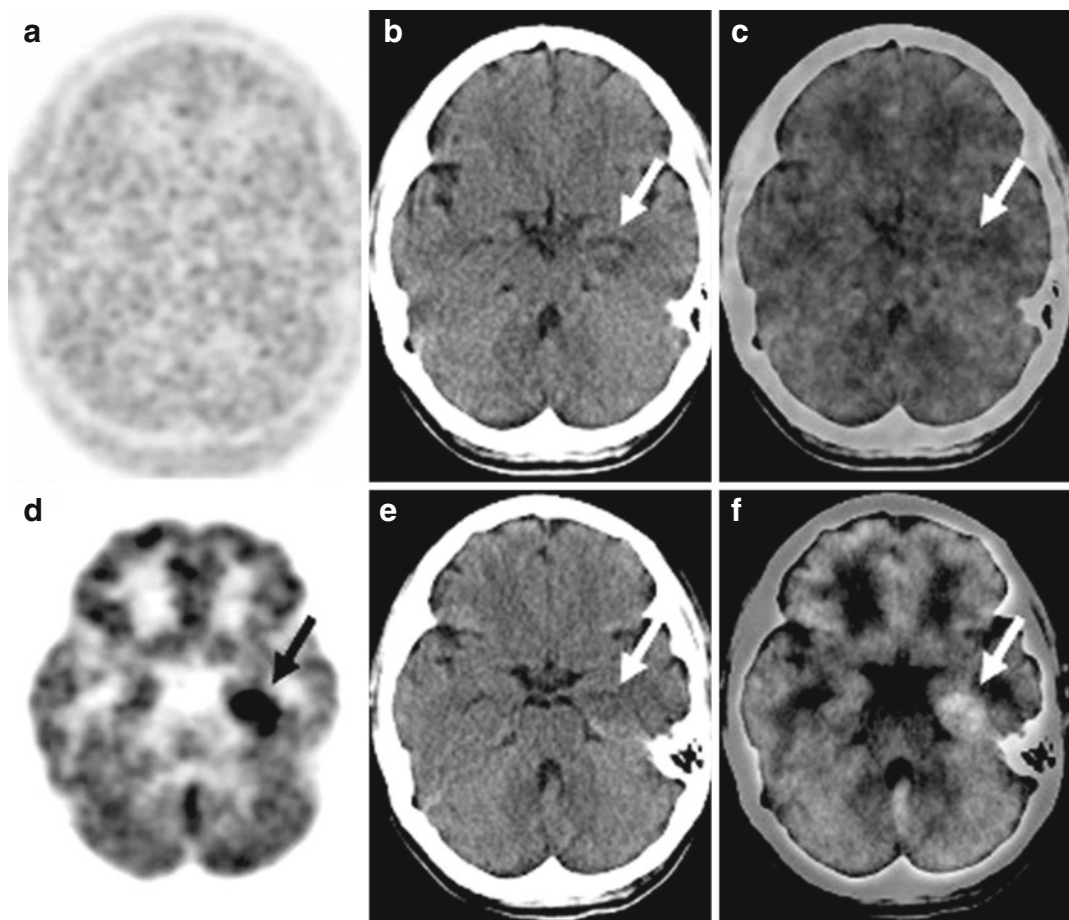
Example of a patient with encephalitis diagnosed after dual tracer brain PET/CT study with [^{11}C]-acetate and [^{18}F]FDG. [^{11}C]-acetate images did not reveal any increased activity (a) in the hypodense lesion in the region of the left hippocampus revealed on the CT (b, *arrow*) and fused PET/CT (c, *arrow*) images. [^{18}F]FDG
